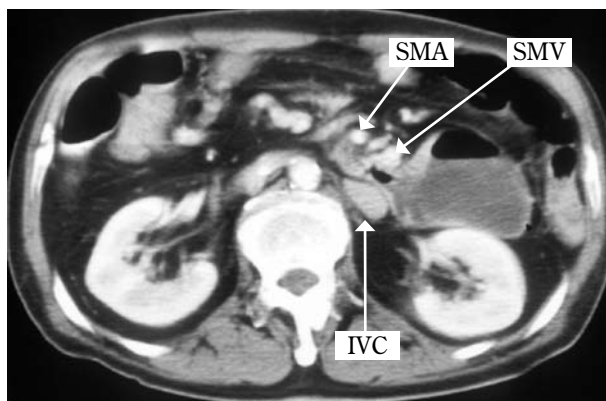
Abdominal CT indicated total situs inversus. Second part of the duodenum was remarkably dilated and narrowed in the aorto-SMA angle, suggesting superior mesenteric artery syndrome. The third portion of duodenum was compressed by sharpness of aorto-SMA angle. SMA: super mesenteric artery, SMV: super mesenteric vein, IVC: inferior vena cava.
